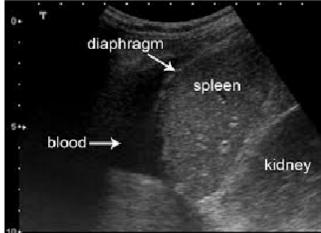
ULTRASOUND IMAGE OF A LEFT HAEMOTHORAX. Blood shows as a dark homogenous zone; you will not be able to differentiate this from other types of effusion.
